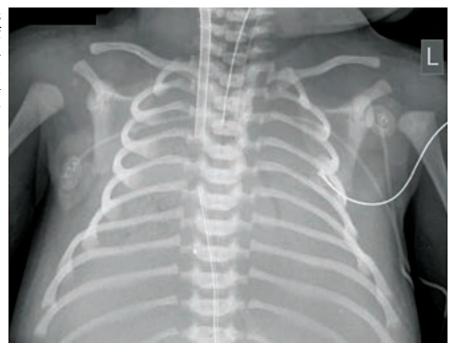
Chest X-ray shows complete white opacities of the lung, with extracorporeal membrane oxygenation cannula, endotracheal tube, and umbilical vein catheter.
